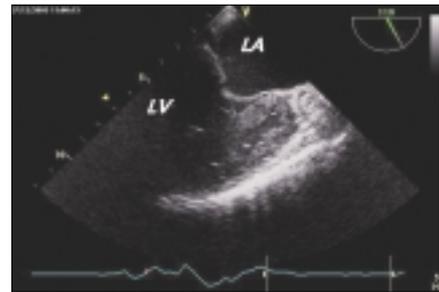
Transesophageal imaging of a middle papillary muscle (arrow) directly attached to the basis of the anterior mitral valve
